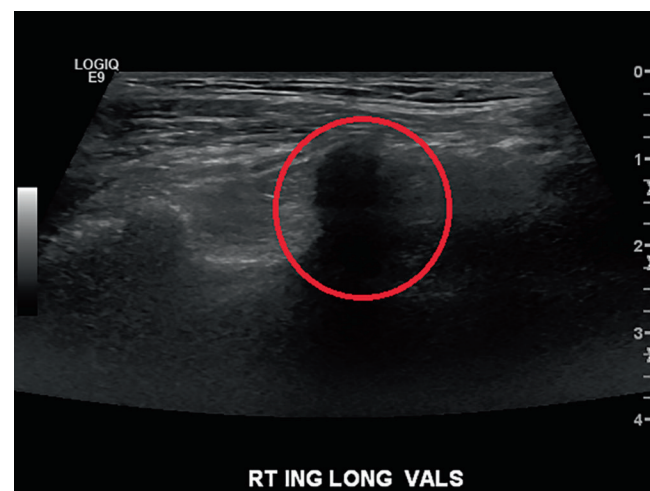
An ultrasound of the groin with a hernia noted within the red circle.
